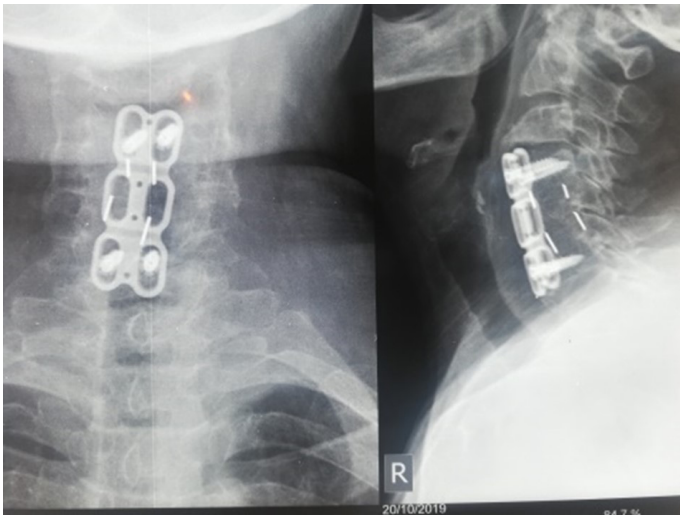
AP and lateral X-ray of cervical spine show bonny fusion at C4 - C5, C5 - C6 ACDF after 2 years of operation.
